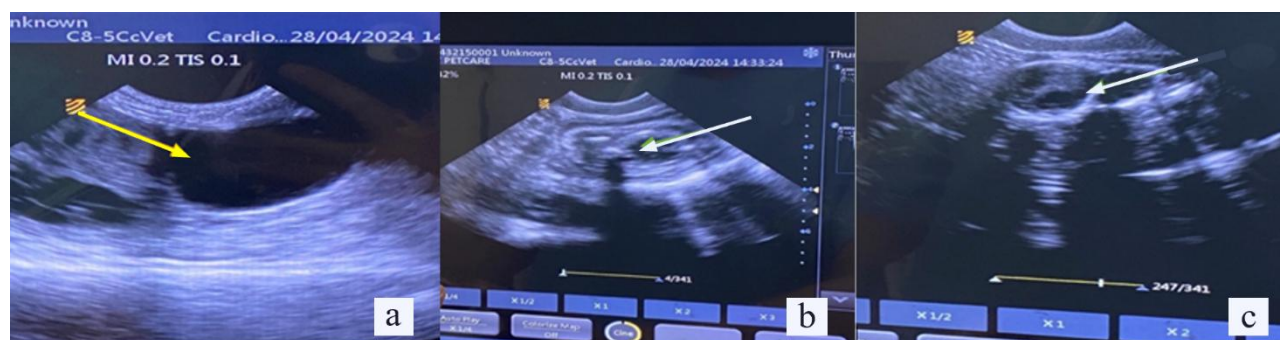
Ultrasonography showing two living fetuses with gestational sacs; yellow arrow indicates the urinary bladder (a); green arrows indicate the live fetuses, fetus 1 (b) and fetus 2 (c)
